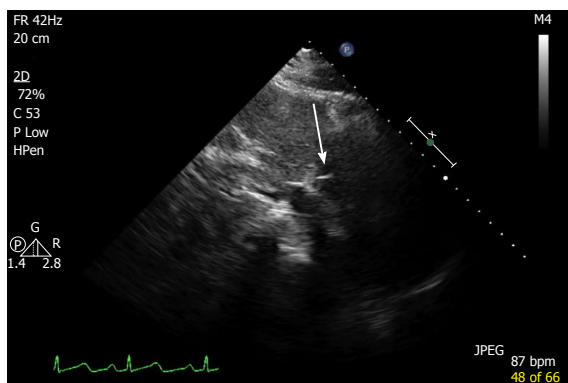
Echocardiography - modified subcostal view showing liner foreign body in the right atrium.
